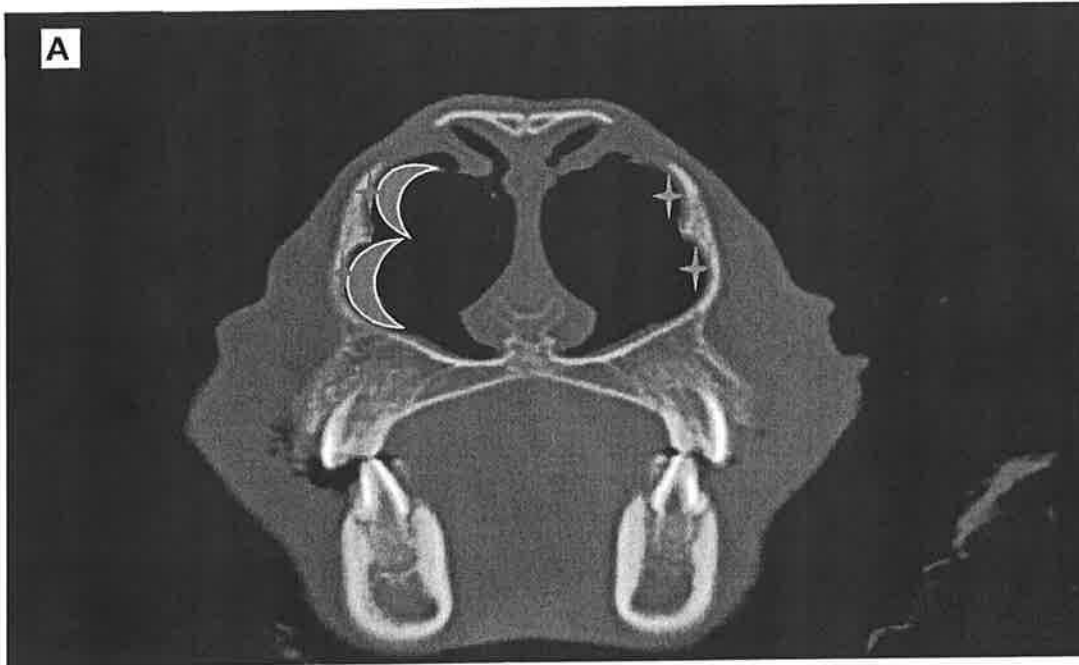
Computer generated images indicating lateral nasal wall injury and packing material insertion. A) CT-scan with stars indicating areas of injury to lateral nasal wall and packing on one side, B) Two injuries on lateral nasal wall separated by remnant crest of bone of middle turbinate.
